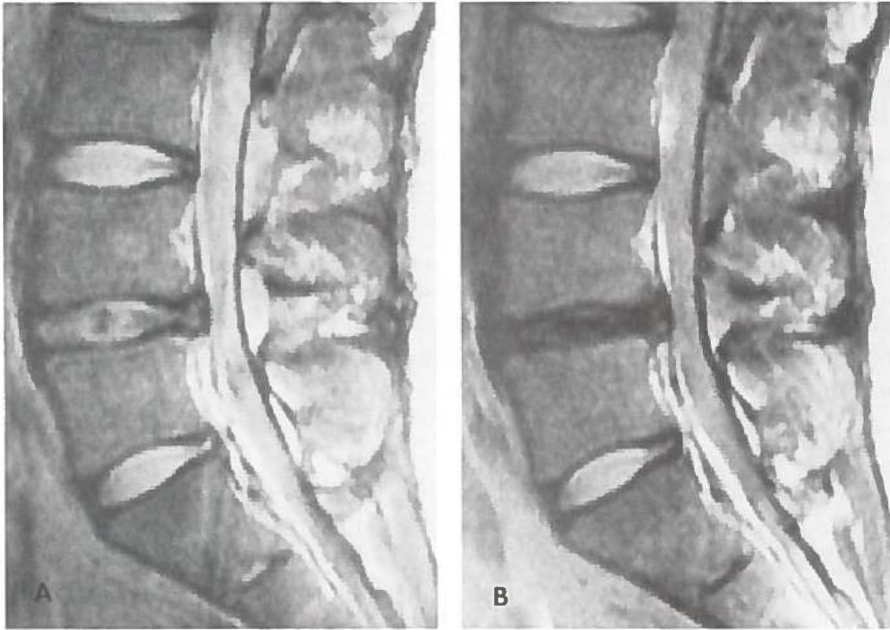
A. MRI scan of a 23-year-old male, demonstrating a herniated disc L4-L5. B. Three months after chymopapain injection of disc L4-L5, the MRI scan demonstrated a marked decrease in signal intensity at that level, consistent with loss of water content.
